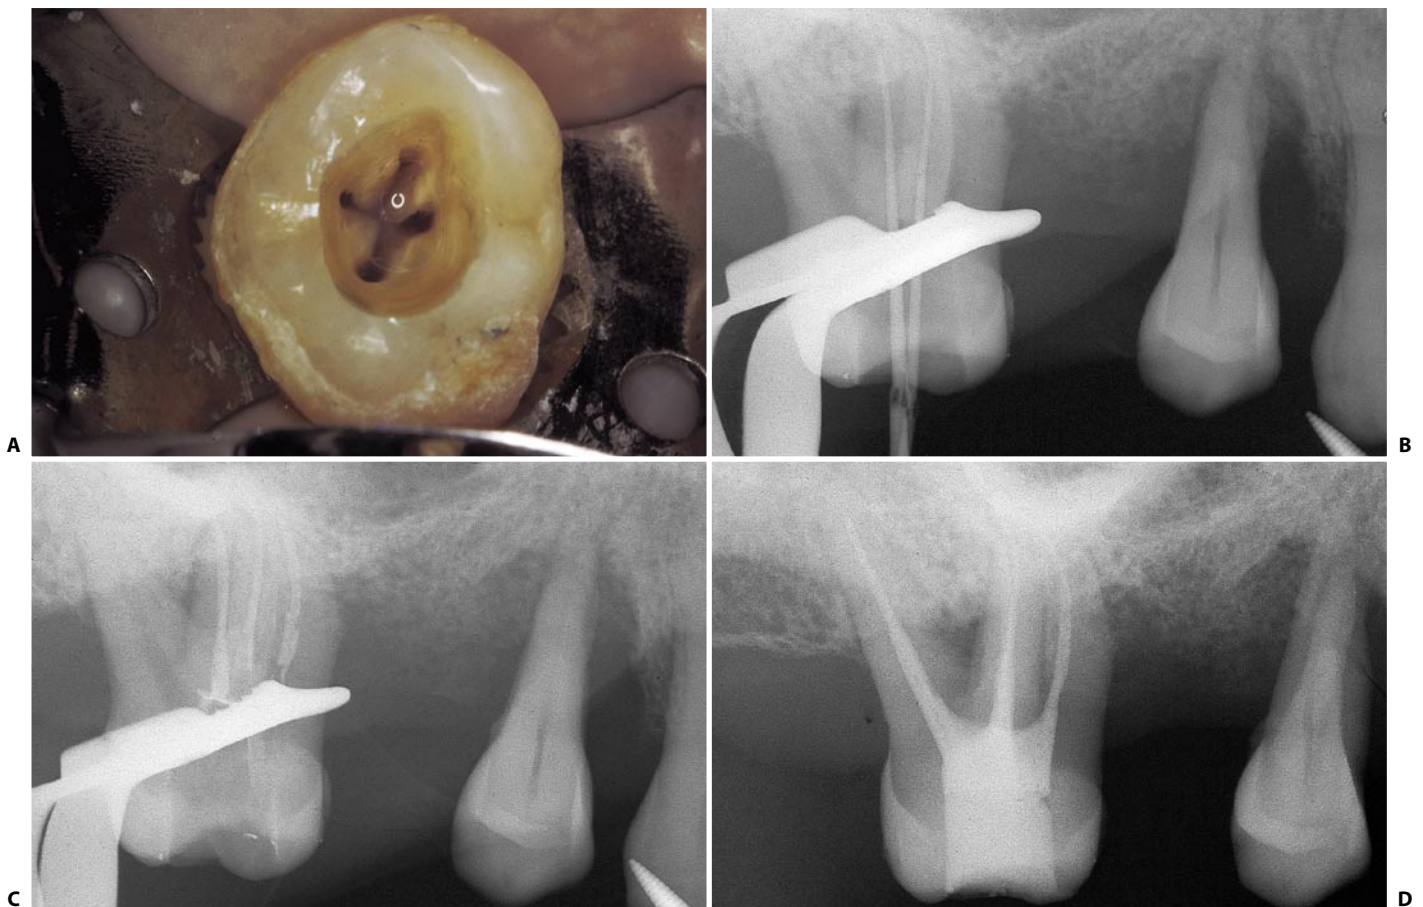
A. Access cavity of the upper right first molar with two palatal canals. B. Intraoperative radiograph reveals two instruments within the two canals of the palatal root. C. Intraoperative radiograph: the two palatal canals and the mesiobuccal canal have been obturated. D. Postoperative radiograph.
